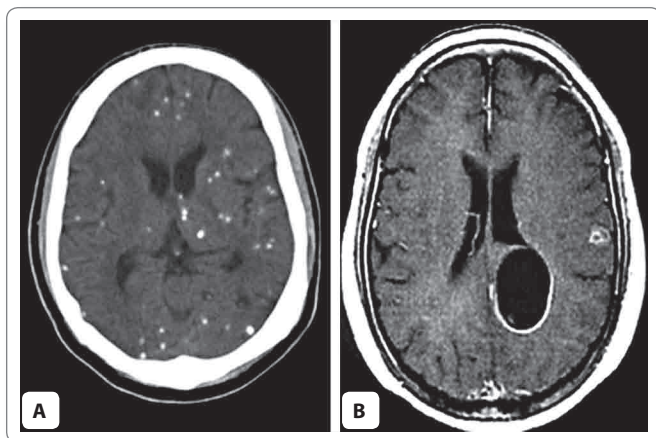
A. CT Scan shows multiple calcified cysts of *Cysticercus cellulosae* in the brain parenchyma; B. CT Scan of brain shows clear cyst wall in a cysticercal lesion
